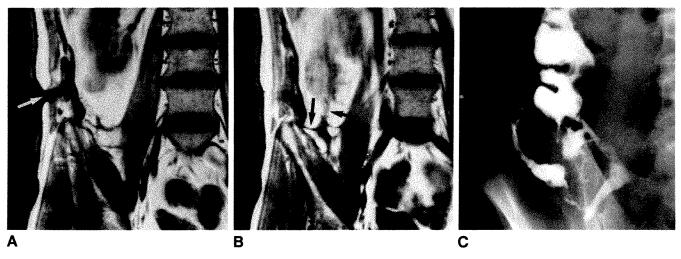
A, Coronal MR image (SE 500/15) in patient with recurrent Crohn disease shows cutaneous opening of fistula in flank (arrow). B, Termination of fistula is seen in region of anastomosis between new distal ileum and ascending colon (arrows). C, Sinogram shows full extent of fistulae. Cutaneous opening is marked by lead ball.
